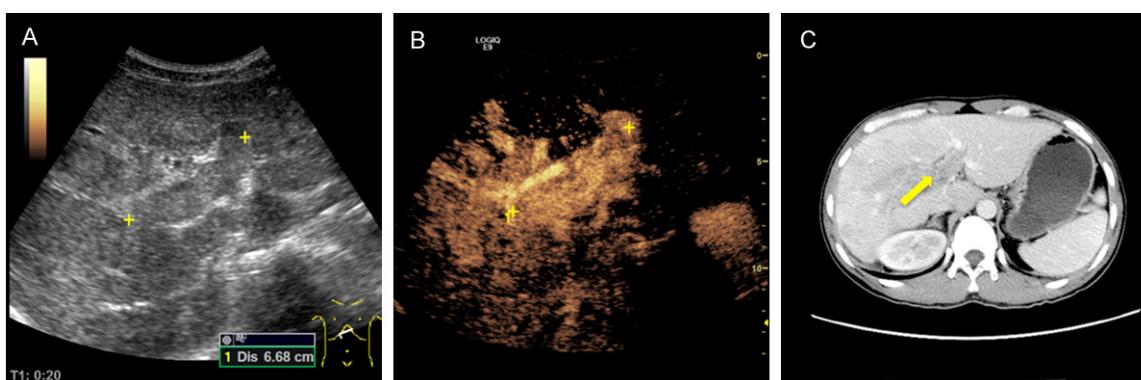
PVTT in left portal vein. A: Conventional ultrasound imaging. B: CEUS imaging. C: Enhanced CT imaging.
